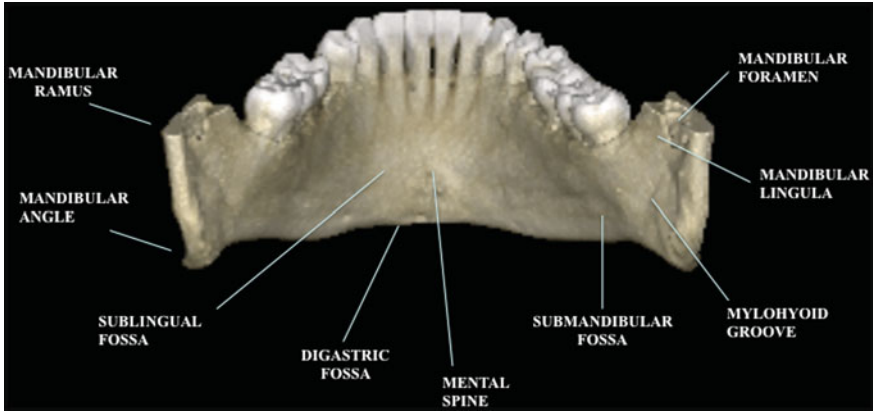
Mandible, CBCT-3D reconstruction; inner surface, posterior view
